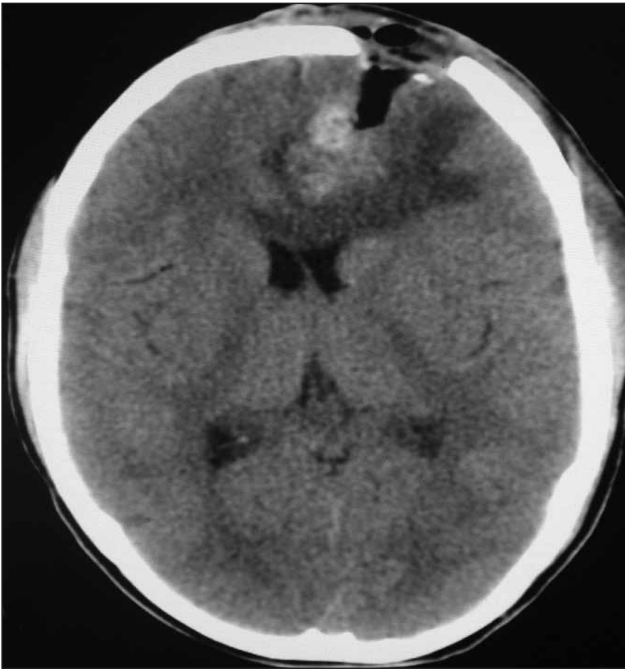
Postoperative CT scan showing complete removal of foreign objects.
